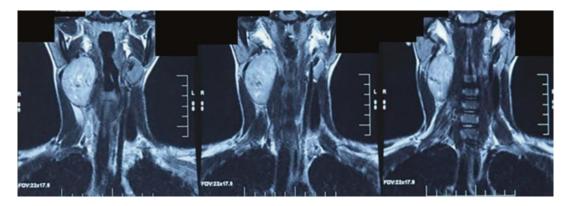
MRI scan: coronal cuts showing the heterogeneous hyperintense lesion in the right sides
